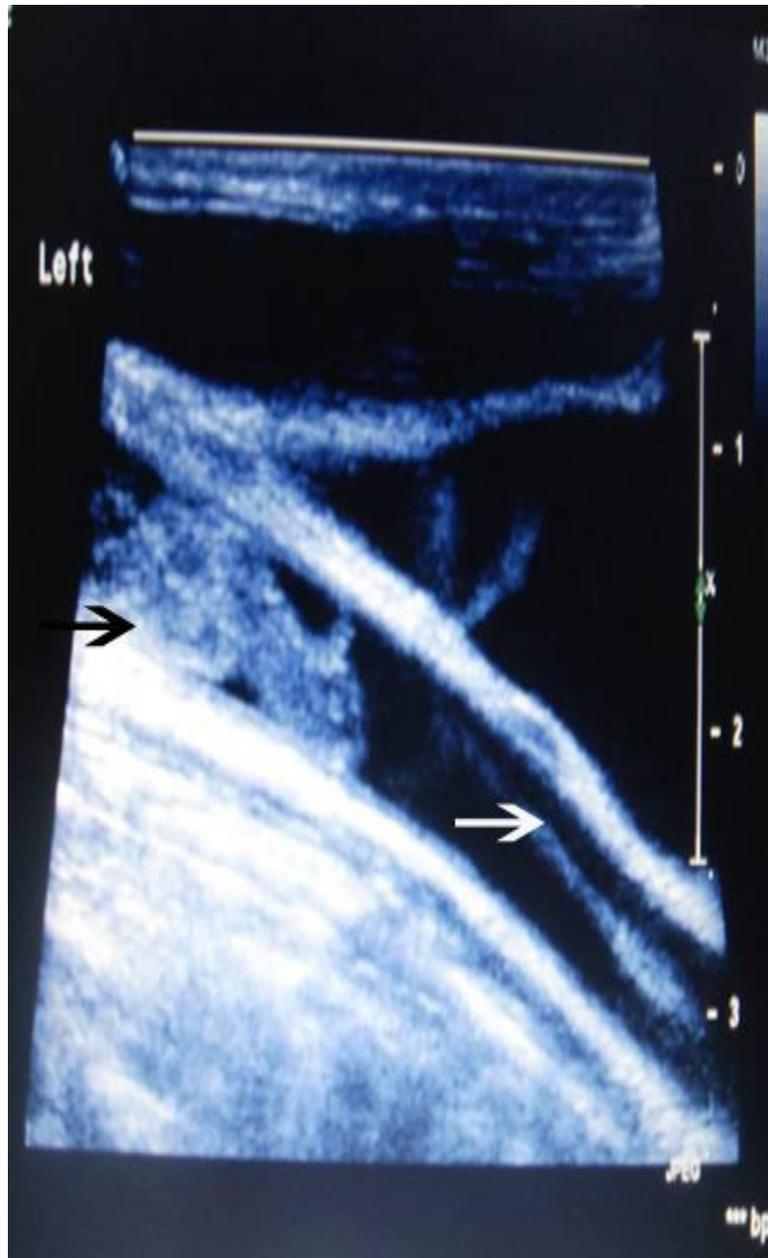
Carotid ultrasonography indicates a left spontaneous common carotid dissection (white arrow) with a thrombosis (black arrow), resulting in the occlusion in the origin of the left internal carotid artery.
